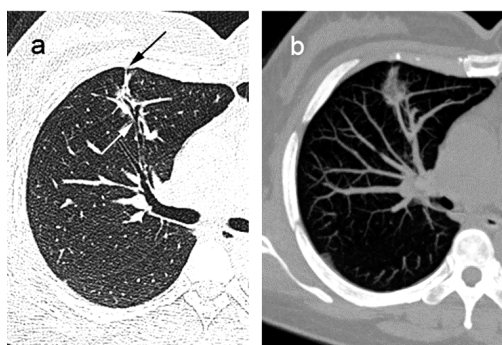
CT characteristics of a 52-year-old female patient with highly differentiated adenocarcinoma of the anterior segment of the right upper lobe. (a) CT plain scan showed that the lesion showed ground-glass density and was about 21.6×11.7 mm in size. The margin was irregular, the air bronchogram sign (white arrow) could be seen in the lesion, and the adjacent pleura was stretched and thickened (black arrow). (b) The MIP reconstruction showed multiple adjacent vessels entering the lesion (tumor vascular sign).
